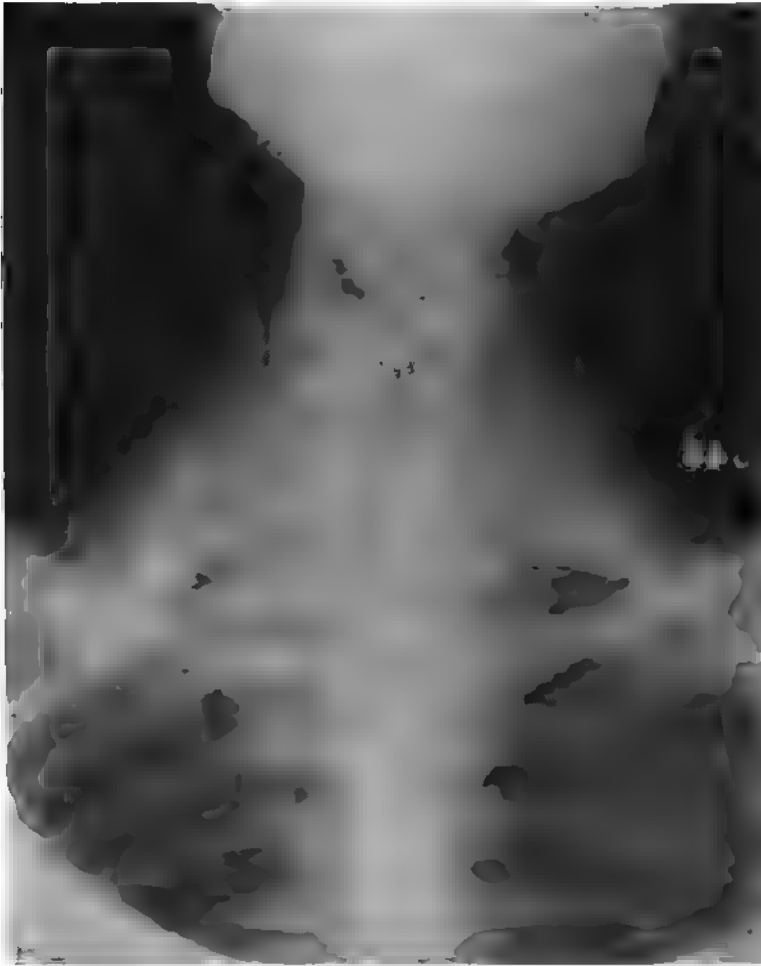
Case No. A57685. X-ray 15046. Mrs. G. L. K., aged forty-five. Came for examination complaining of indigestion. Probable cholecystitis. Adenomas of thyroid. Slight numbness in the right little and ring finger, also in right little toe and fourth toe. X-ray disclosed well-marked right seventh cervical rib. Rudimentary on the left. Rib barely palpable. Operation not advised.
